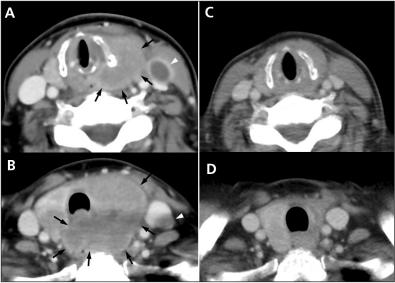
Computed tomographic (CT) images at (A) the level of the cricoid cartilage and (B) the level of the cervical trachea of the neck of a 67-year-old woman, showing a large mass involving the left lobe of the thyroid gland (arrows) and the cricoid cartilage. Lymphadenopathy (white arrowheads) and mass effect on the esophagus are also evident. (C and D) Follow-up CT images showing resolution of the thyroid mass and lymphadenopathy one and a half months following withdrawal of methotrexate.
